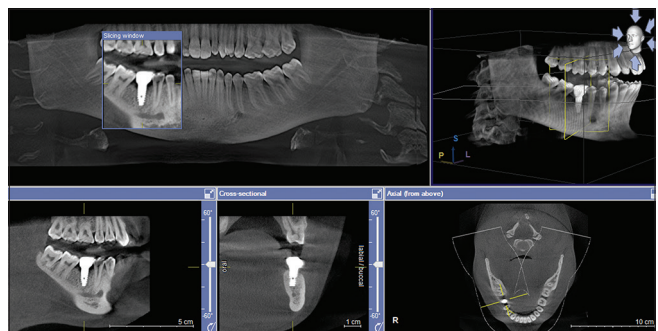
12-month postoperative cone-beam computed tomography
